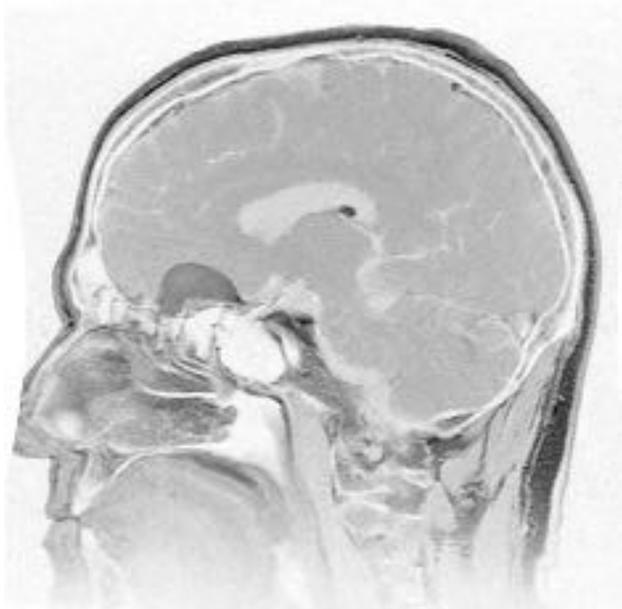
Sagittal postcontrast T1-weighted magnetic resonance images of a small olfactory groove meningioma. Property of the Division of Neurosurgery, University of British Columbia. Used with permission.
